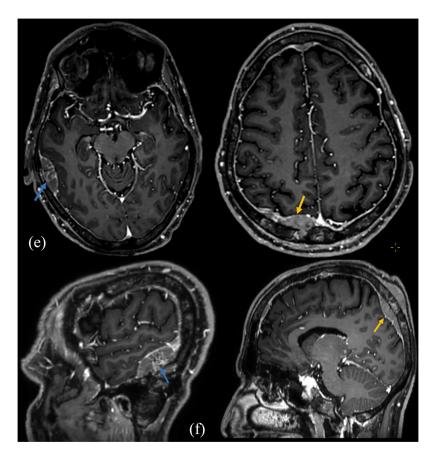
Brain MRI showed two extra-axial lesions of the right temporal lobe (blue arrow) and the right parieto-occipital region (orange arrow), in iso signal T2 (A: axial section), iso signal flair (B: coronal section), with loss zones of signal in T2* (C: axial section). It is in restricted diffusion (ADC low at 0.33×10^{-3} mm²/s) in axial section (D), heterogeneously enhanced after injection of the gadolinium in axial (E) and sagittal (F) section.
